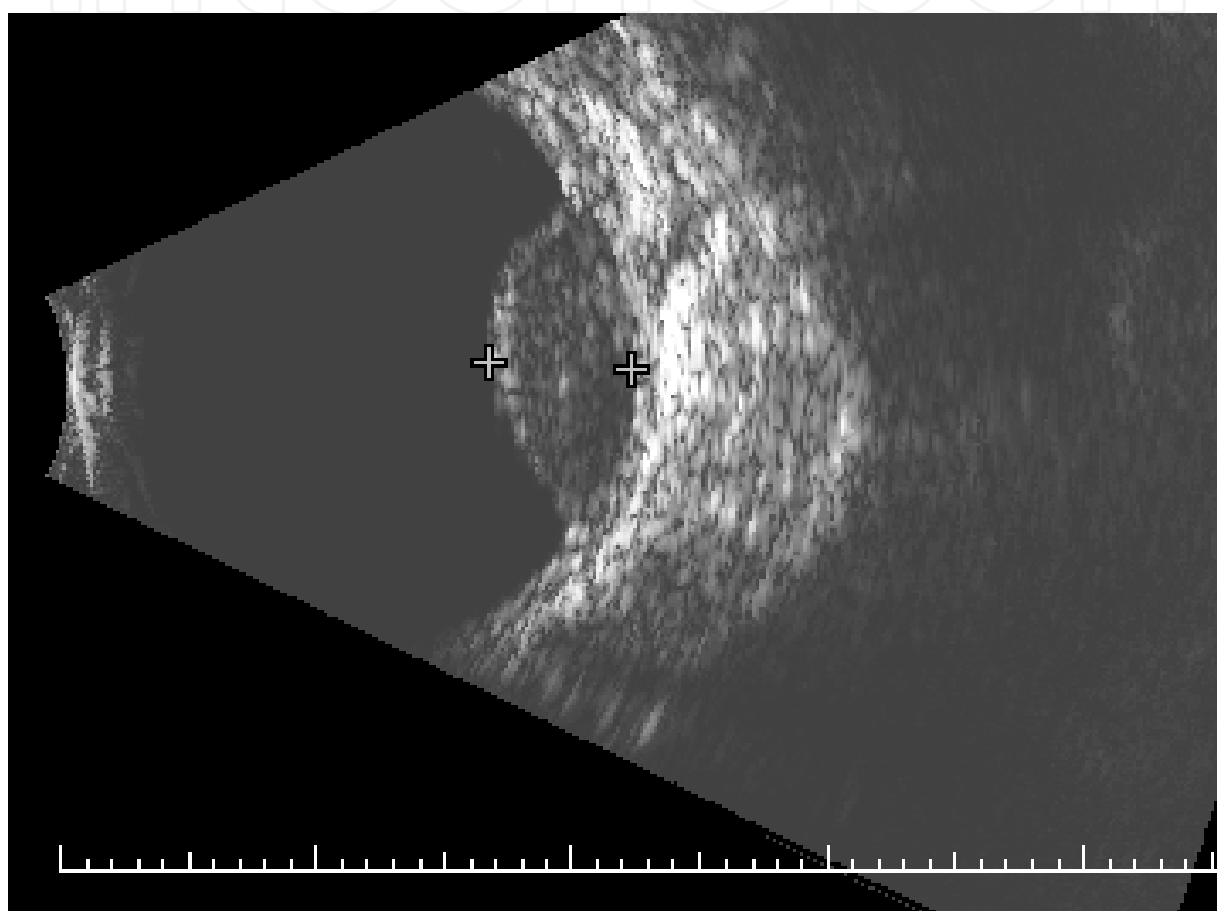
B-scan ultrasound of the tumor in Figure 2E after plaque surgery just before cataract surgery with an apical height of 5.8 mm.
